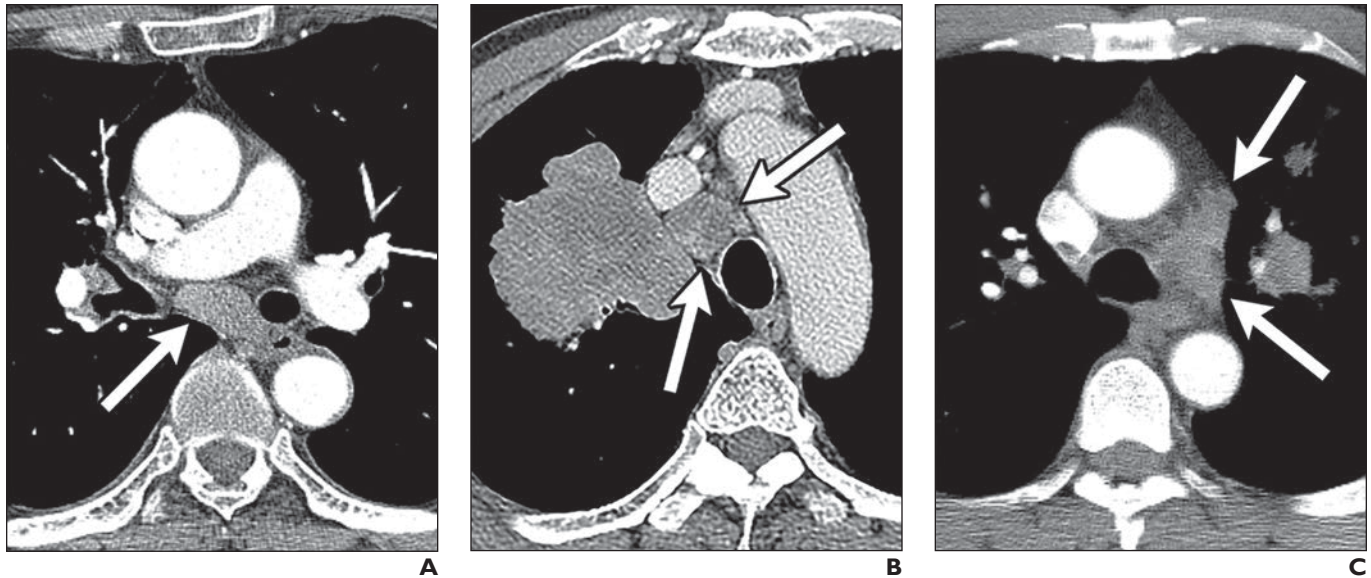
Axial images from contrast-enhanced staging chest CT examinations in three patients with non-small cell lung cancer show representative examples of overall impression for radiologic extranodal extension (ENE).
